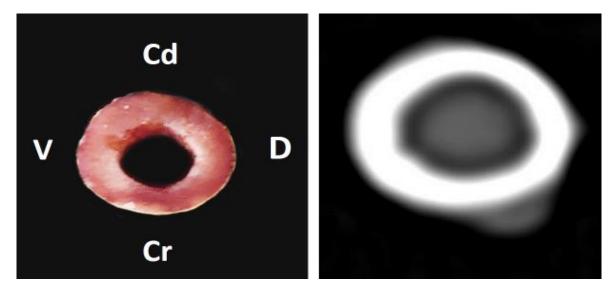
The cross-sectional view of right humerus (photograph and CT scan)
